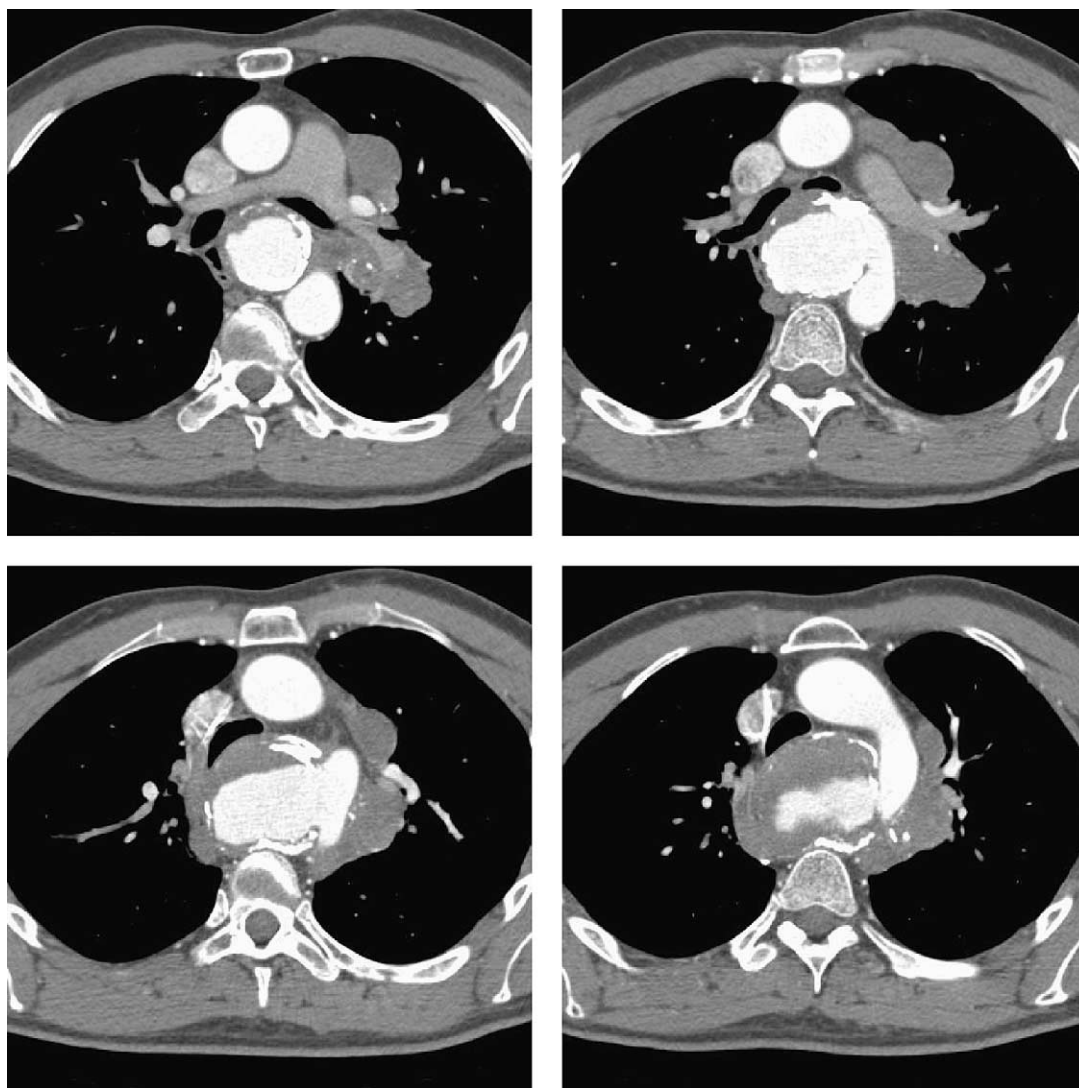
Representative slices of thoracic CT scan, demonstrating thoracic aortic pseudoaneurysm.
